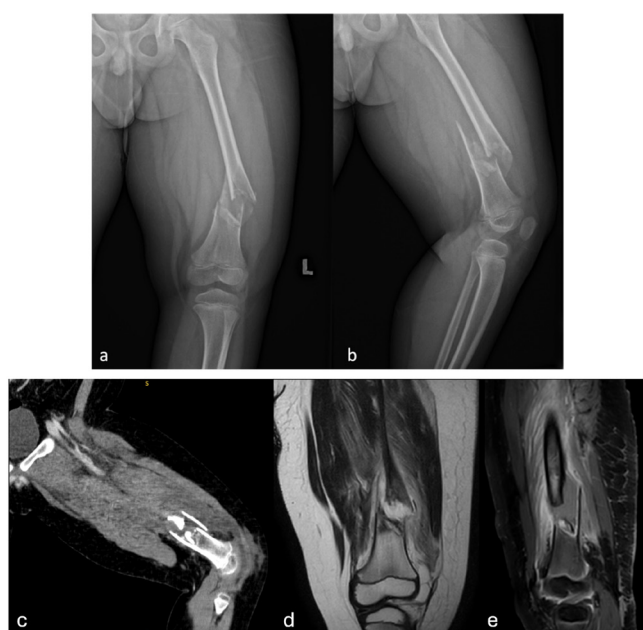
(a,b) Anteroposterior and lateral radiographs of the left femur showing a comminuted distal third femur fracture through a centrally located lytic lesion, approximately 3cm proximal to distal femoral physis. The lesion exhibits a narrow zone of transition with visible fallen fragments. (c) Sagittal CT scan highlighting the characteristic "fallen fragment" sign within the cyst. (d) MRI T2-weighted image (T2W) of coronal view demonstrating a relatively well-defined lesion with a hyperintense signal at the fracture site. (e) Gadolinium-enhanced MRI (Gado), shown in sagittal view, confirming peripheral rim enhancement.
